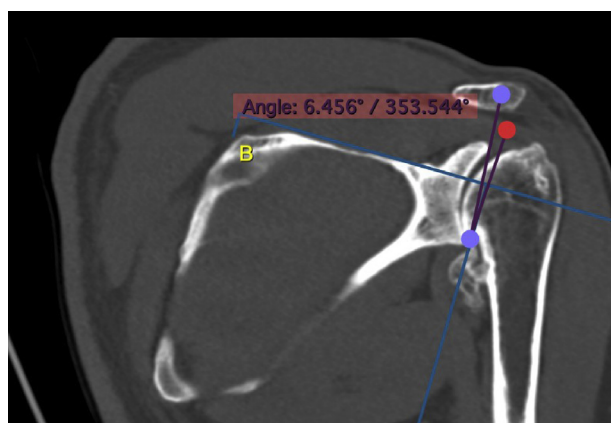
Representative shoulder coronal computed tomography slice oriented in the plane of the scapula used for measurement of glenoid inclination. A line along the supraspinatus fossa was used, and the angle between the perpendicular line to the supraspinatus fossa and a line connecting the superior and inferior portion of the glenoid produced the glenoid inclination measurement.
